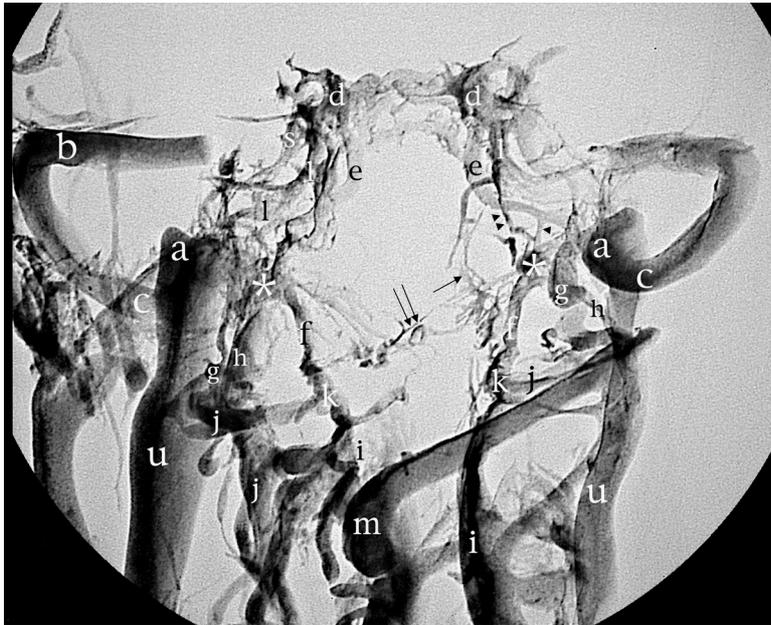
Standard radiographic picture of the corrosion cast from Figure 21 in the antero-posterior projection, showing the ACC and its relation with surrounding veins. The proximal portions of the transverse sinus, confluens sinuum, straight and superior longitudinal sinuses have been removed for better visualization. Arrowhead - branch between IPS and ACC; double arrowhead – inferior petro-occipital vein; arrow - basilar plexus; double arrow - branch to prevertebral venous plexus. a, bulb of IJV; b, TS; c, SS; d, CS; e, IPS; f, anterior condylar vein; g, posterior condylar vein; h, lateral condylar vein; i, anterior IVVP; j, VAVP; k, anastomosis between anterior IVVP and VAVP; l, carotid artery venous plexus of Rektorzik; m, deep cervical vein; u, IJV.
